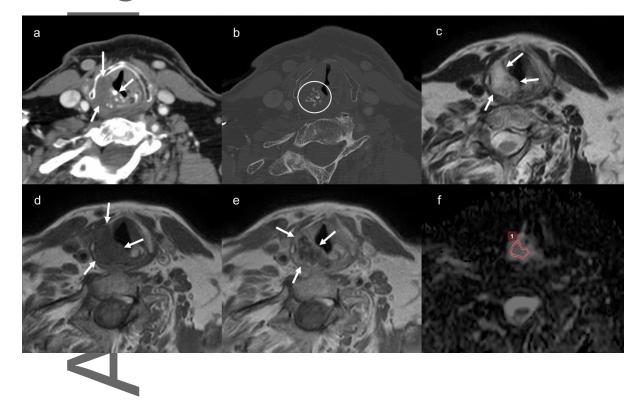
A laryngeal conventional chondrosarcoma in a 78-year-old male patient (case 2). Contrast-enhanced CT (a) shows a low-density mass (arrow) with a well-defined margin on the right side of the ericoid cartilage with minimal enhancement, calcification, and cortical defect/expansion. Bone window CT (b) shows coarse, granular calcification (within the circle) inside the lesion. The internal part of the lesion shows high signal (c) on T2-weighted image (arrow) and low signal (d) on T1-weighted image (arrow). Gadolinium contrast-enhanced T1-weighted image (e) shows mild and heterogeneous enhancement with peripheral predominance (arrow). The apparent diffusion coefficient (ADC) map (f) shows a high ADC value of 1.76×10^{-3} mm²/s in the region of interest.
